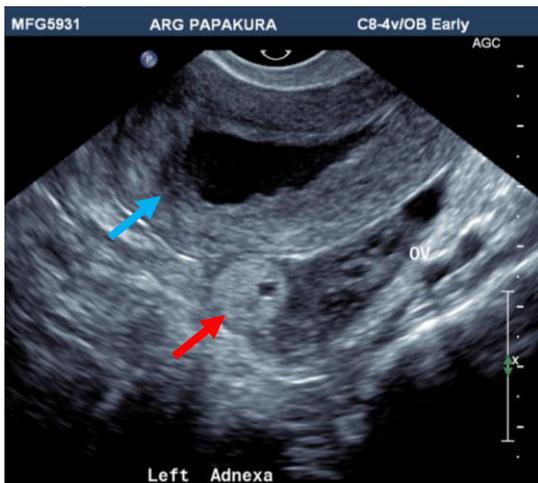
Transvaginal ultrasound of tubal pregnancy of 19mm diameter, adjacent to the left ovary (red arrow) with fluid and pseudodecidual changes in the uterus (blue arrow)
